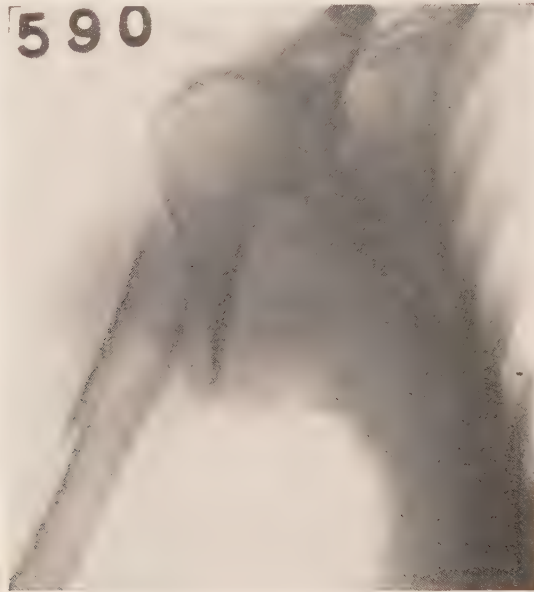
Spiral comminuted fracture of the upper third of the humerus. (Roentgenogram by Dr. G. C. Bird.)
